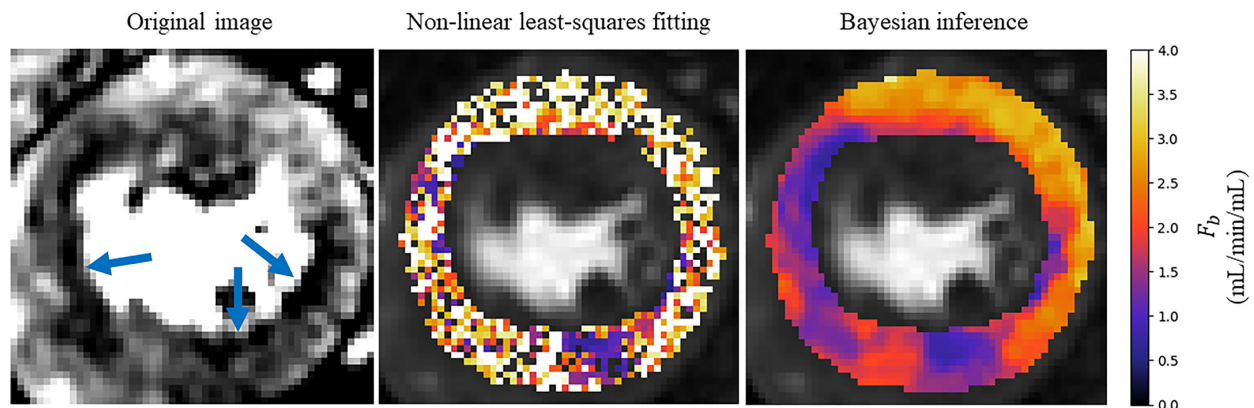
An example slice where the Bayesian fitting (right) has correctly identified ischaemia but the noisy least squares fitting (middle) makes it difficult to identify the ischaemia, particularly in the infero-septal wall. The identified areas of ischaemia are indicated on the original MR image (left).
